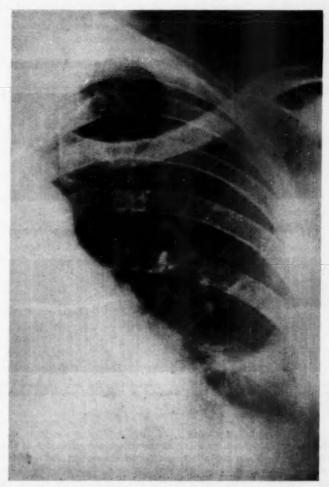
X-ray showing the left heart border (November 21, 1949) characterized by fixed scalloped edges extending from the pulmonary conus down to the apex. Diminished density of the border zone formed by pericardial thickening.
